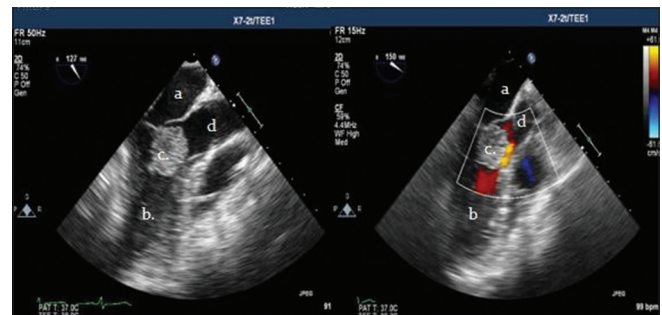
Mid esophageal long-axis view on transesophageal echocardiography showing (a) left atrium, (b) left ventricle, (c) myxoma, (d) left ventricular outflow tract. Color Doppler image is shown on the right
